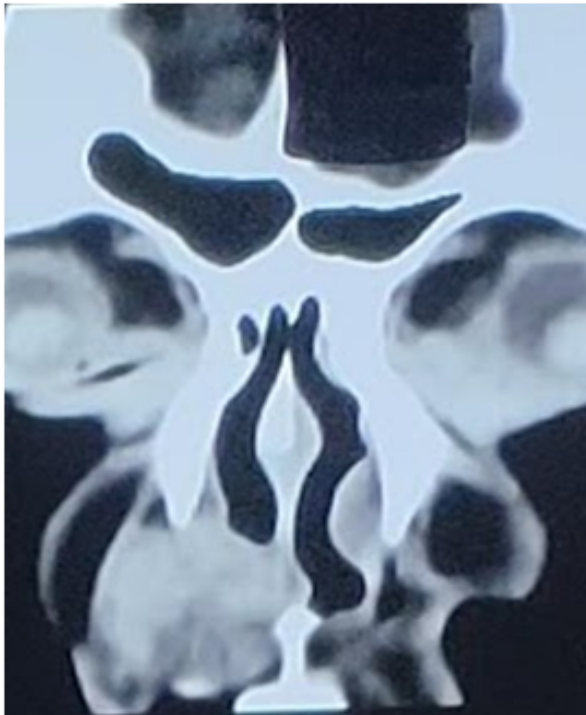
Coronal view CT scan: A well-defined hyperdense lesion with cystic internal content at right nasolabial region bulging into the nasal vestibule and nasal cavity. No bony erosions.
